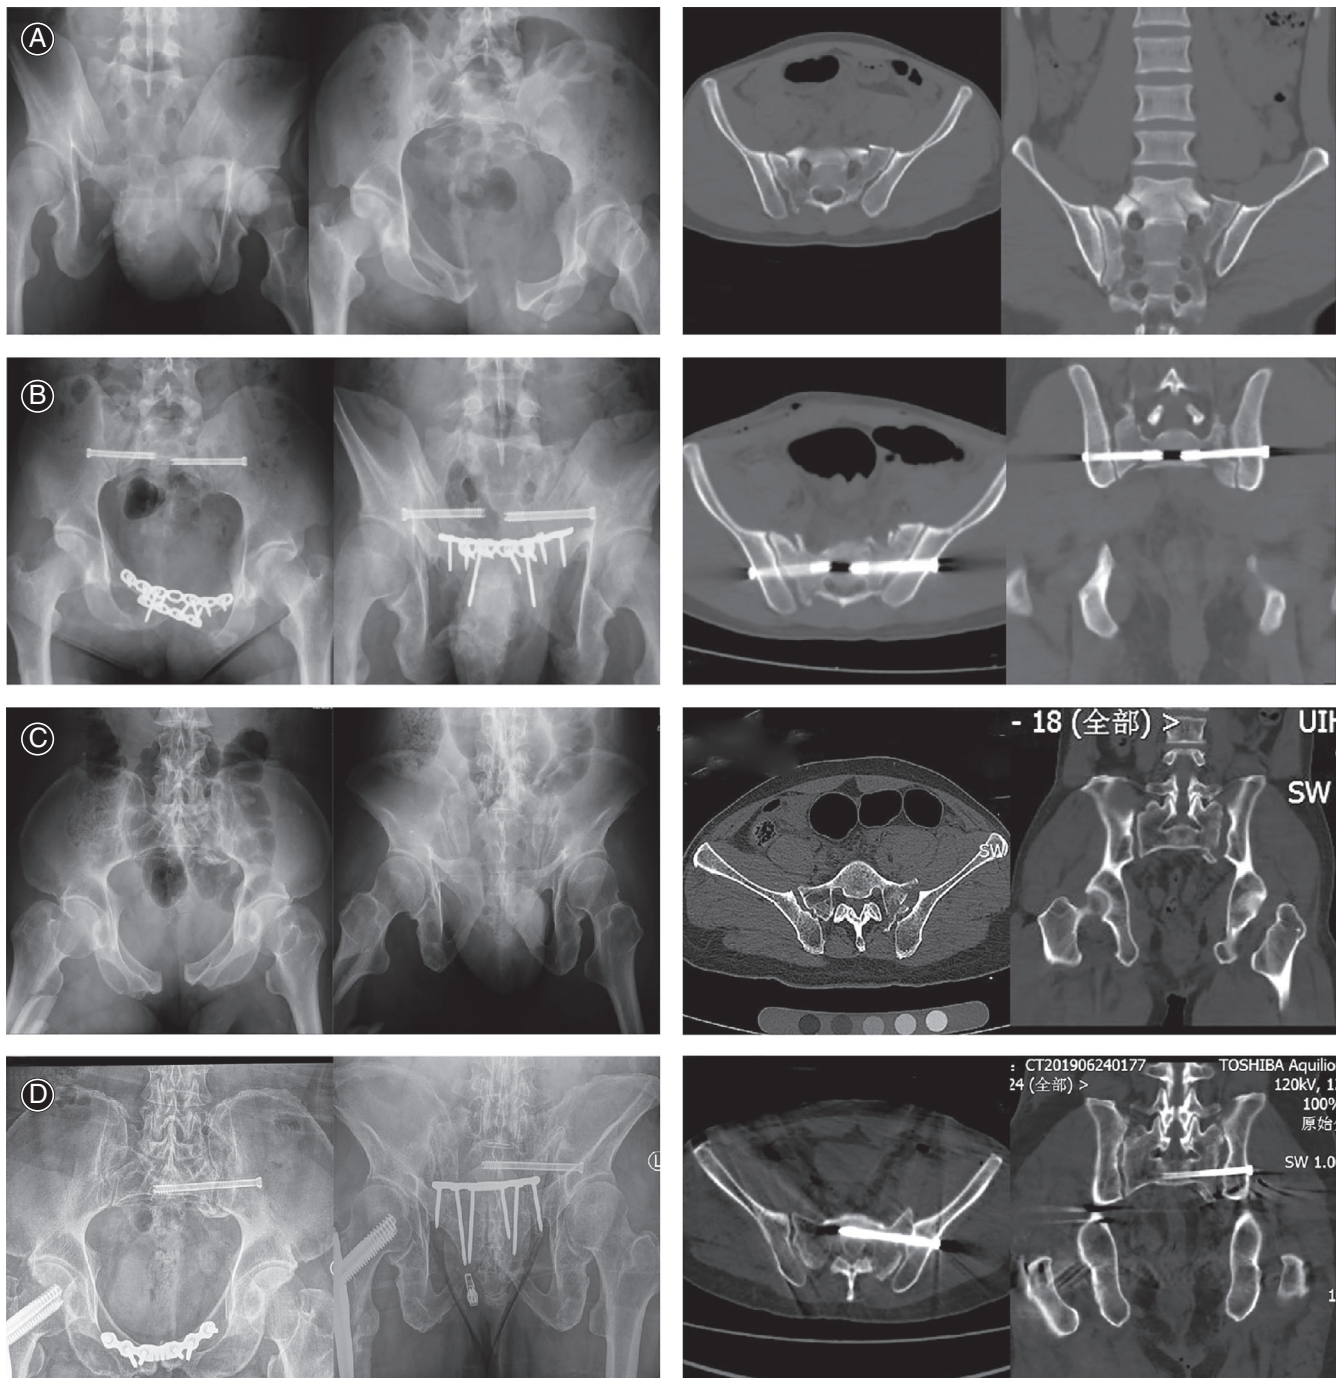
Typical cases. (A and C) Preoperative X-ray, transverse and coronal views of preoperative CT scan showed posterior pelvic fracture and separation of sacroiliac joint. (B and D) Postoperative X-ray showed fractures were well-reduced. Transverse and coronal views of postoperative CT scan showed S₂ IS screws were completely within the cancellous bone.
